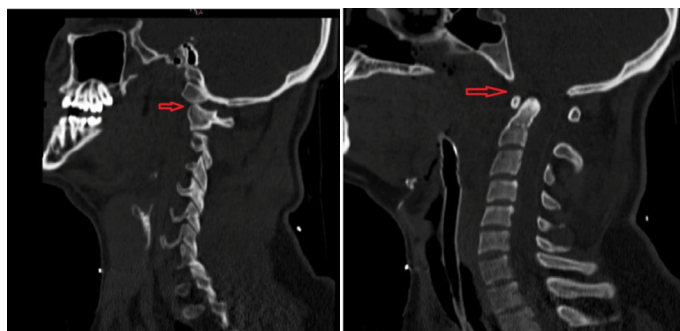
Preoperative CT scans of patients with TAOD.
